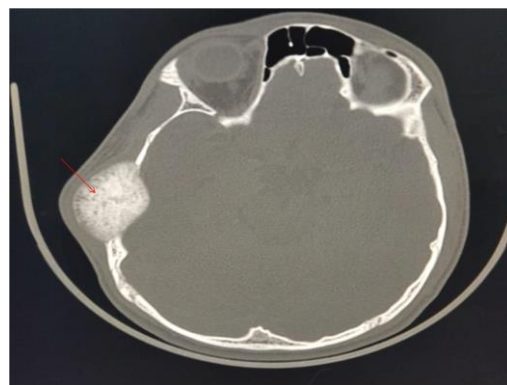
Preoperative CT scan of the brain showing an expansile mass in the skull vault over the right temporoparietal convexity (arrow).
